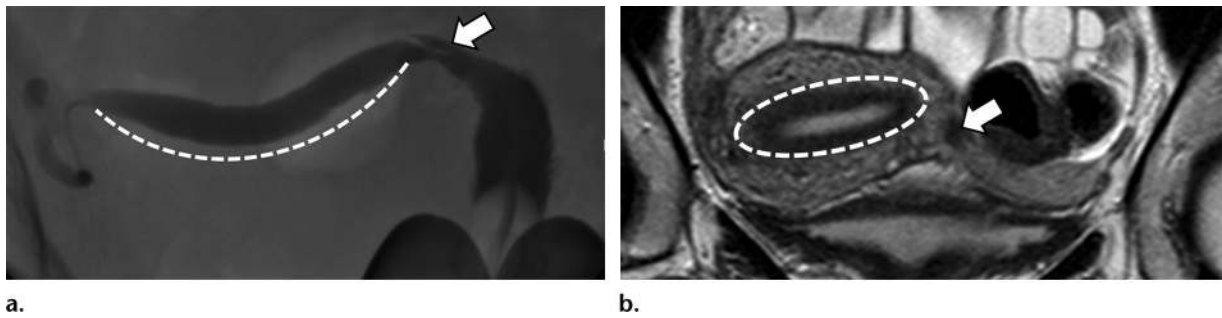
Multimodality imaging of unicornuate uterus in a 35-year-old woman. (a) HSG image shows a right unicornuate uterine cavity (dashed line). In the lower segment, there is a linear filling defect (arrow), which may represent the origin of a rudimentary left cavity. (b) Coronal T2-weighted MR image shows the cavity (dashed line) as well as the general uterine configuration. A rudimentary horn is present, but there is no endometrial tissue or communication (arrow).
